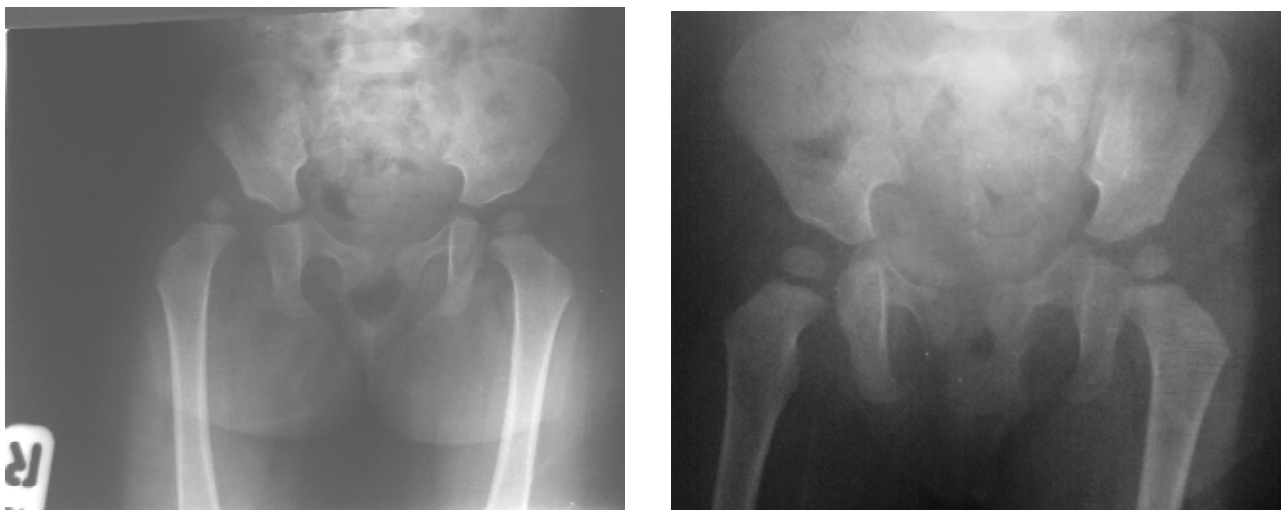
AP x-ray of the patient that shows posterior hip dislocation (left), and after closed reduction (right).
